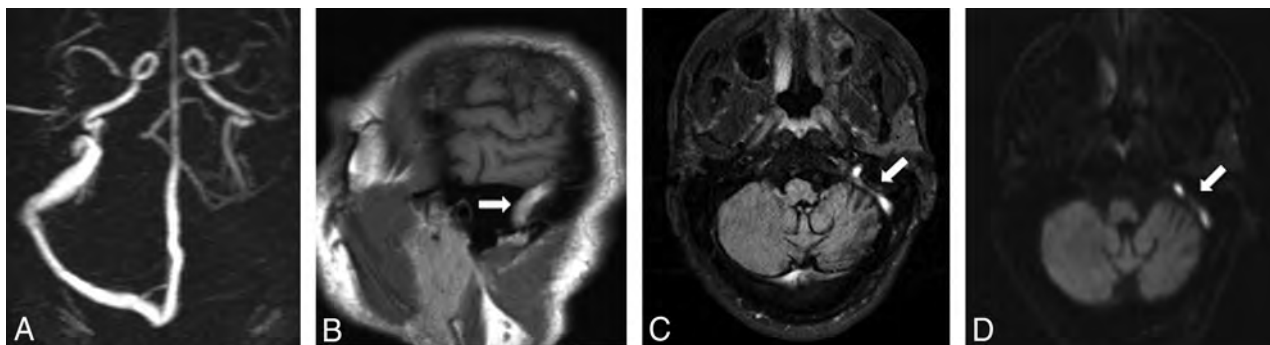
Absence of the left transverse and sigmoid sinuses on PC-MRV (A). Abnormal hyperintense signal in the left transverse and sigmoid sinuses on sagittal T1 (B, arrow) and axial FLAIR sequences (C, arrow) with corresponding high signal on DWI (D, arrow).
